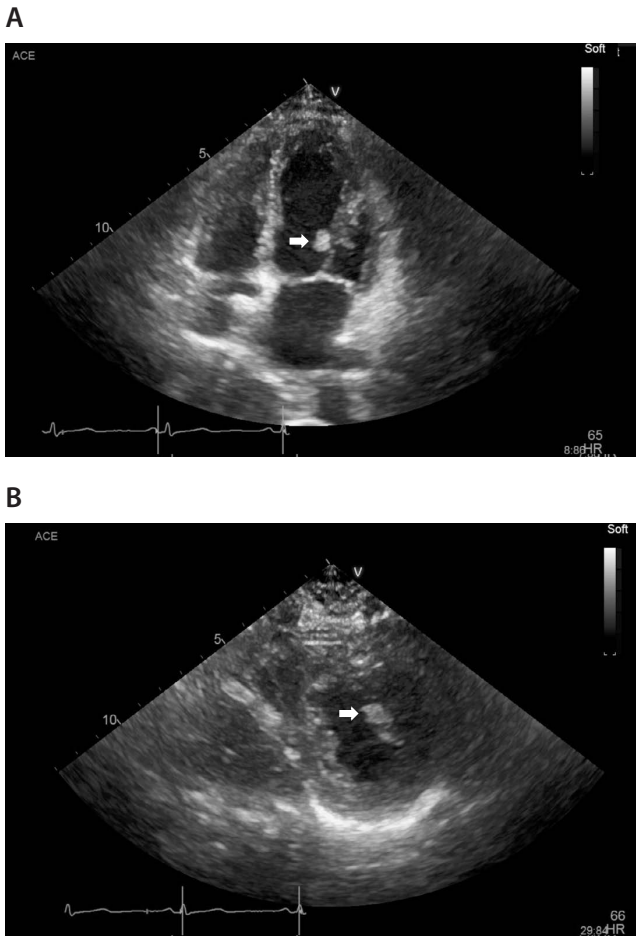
Transthoracic Echocardiogram Showing a High-echoic Mass (Arrow) Arising from the Head of the Anterolateral Papillary Muscle
